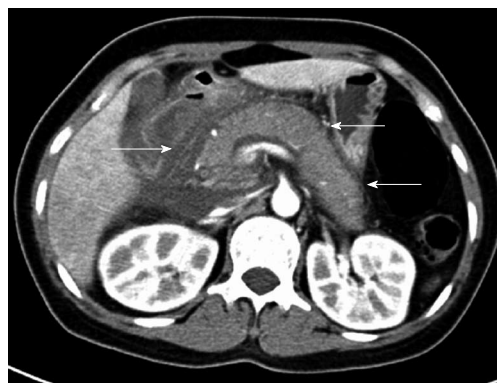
Contrast-enhanced computed tomography. Image showing the swelling of the pancreas with peri-pancreatic exudation and liquid collection (arrows). Grade E acute pancreatitis was diagnosed based on the computed tomography severity index.
